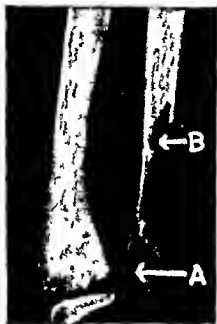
Polyostotic Fibrous Dysplasia. X-ray Film of the Forearm to Show That Some Bone Lesions May Be the Result of a Dysechondroplasia.
